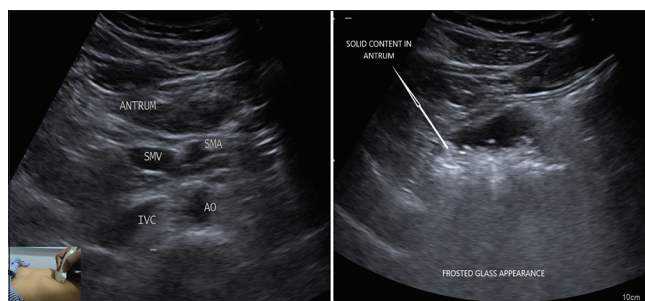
Gastric ultrasound to assess prandial status. AO: Aorta, SMA: Superior mesenteric artery, SMV: Superior mesenteric vein, IVC: Inferior vena cava
